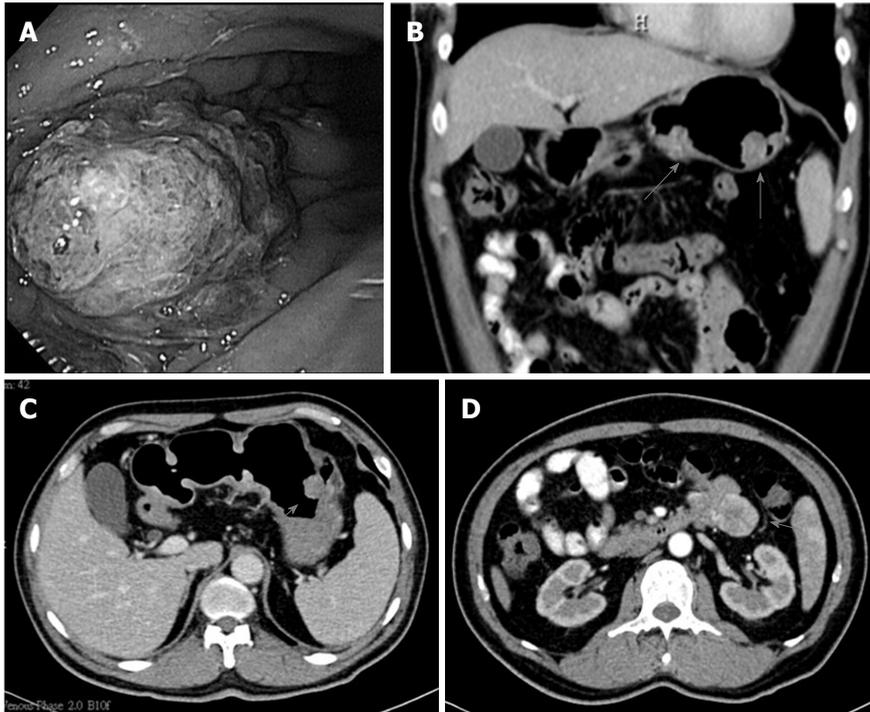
Endoscopic findings and computed tomography scans of the abdomen of the patient at the diagnosis of gastric cancer. A: Multiple polyps in the gastric body and duodenal bulb were demonstrated by EGD; B: The coronal and C: sagittal views from the CT scan; D: An exophytic mass measuring about 3.7 cm × 3.5 cm was incidentally found in the proximal jejunum by CT. CT: Computed tomography; EGD: Esophagogastroduodenoscopy.
